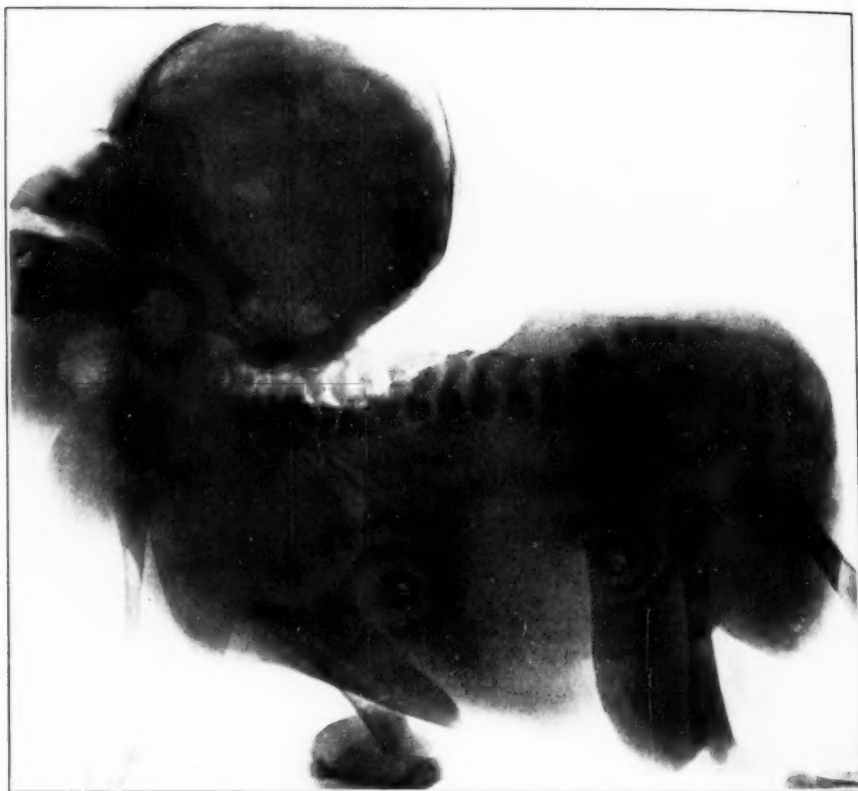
X-ray—lateral view.
